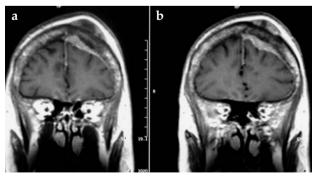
Postcontrast images, (a) coronal T1-weighted spin echo and (b) sagittal T1-weighted spin echo images demonstrating destructive lesion of the diploic mass, leptomeningeal thickening and contrast enhancement, and extension of the lesion to subcutaneous tissue
